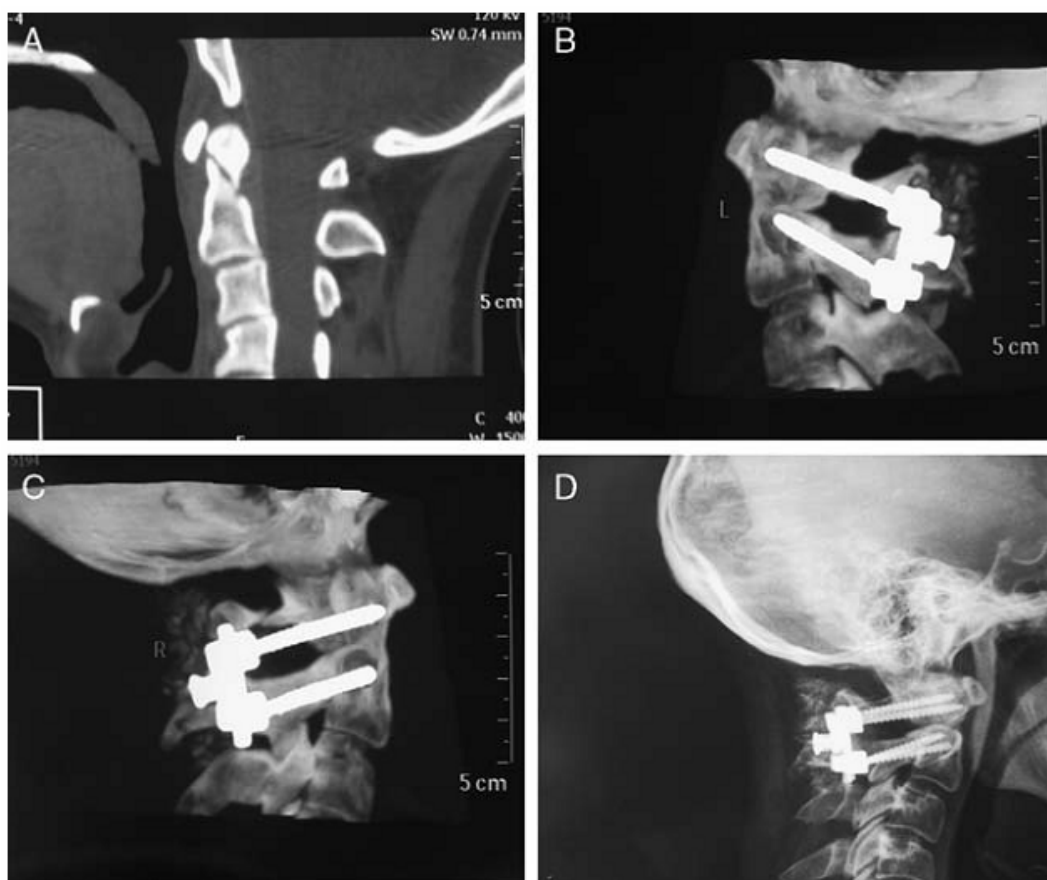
A 27-year-old man who presented with an odontoid fracture underwent atlantoaxial fusion and internal fixation (A). Sagittal reconstruction computed tomography scans show atlas transposterior arch lateral mass screw and axis pedicle screw fixation (left) (B), and atlas lateral mass screw and axis pedicle screw fixation (right) (C). Postoperative lateral x-ray of atlantoaxial internal fixation(D).
